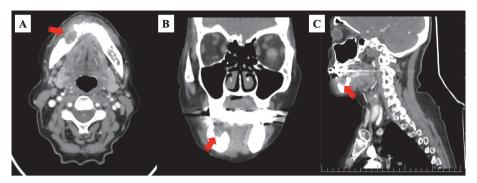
Cone beam computed tomography. Images showing extensive bone resorption and sequestration of osteoradionecrosis in the right mandibular premolar region (red arrows). A: axial; B: coronal; C: sagittal.
